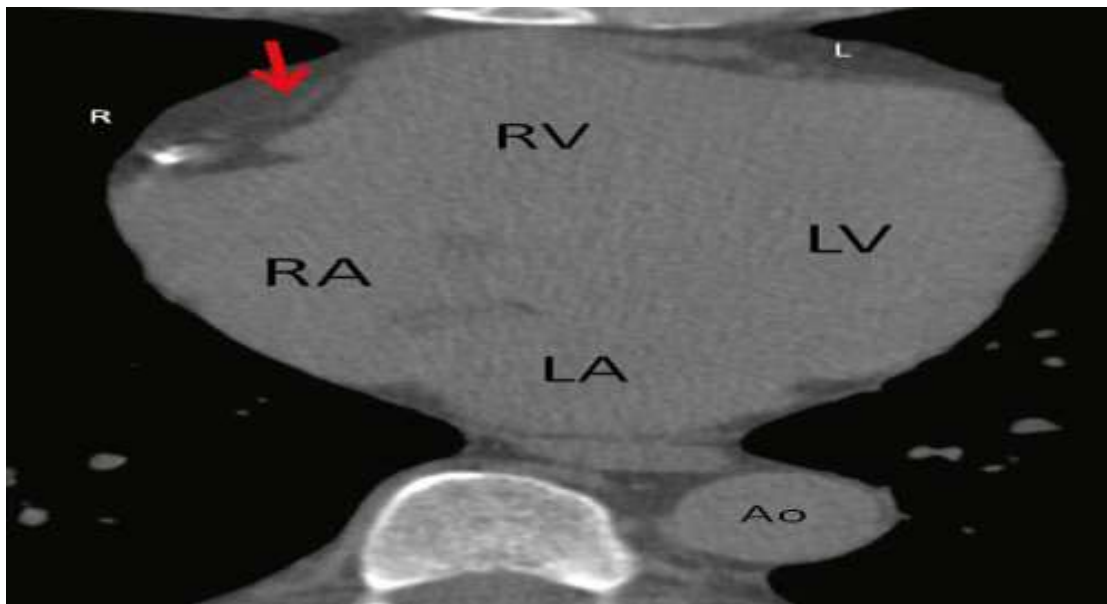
A non-contrast CT scan of the heart.
